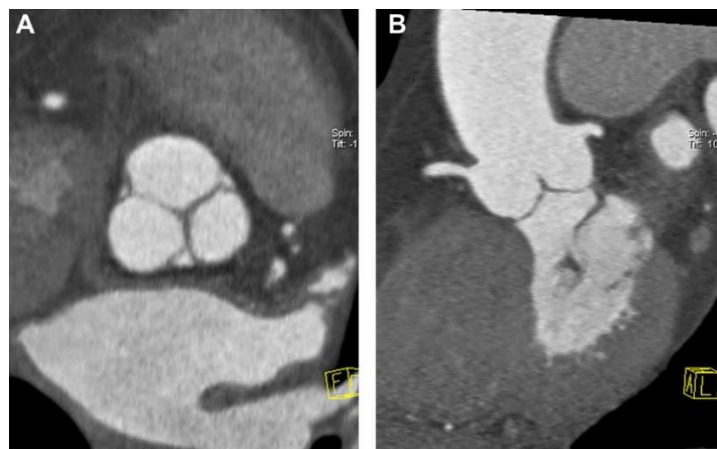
CT provides 3D high spatial resolution images: aortic valve (A) and aortic root (B)
